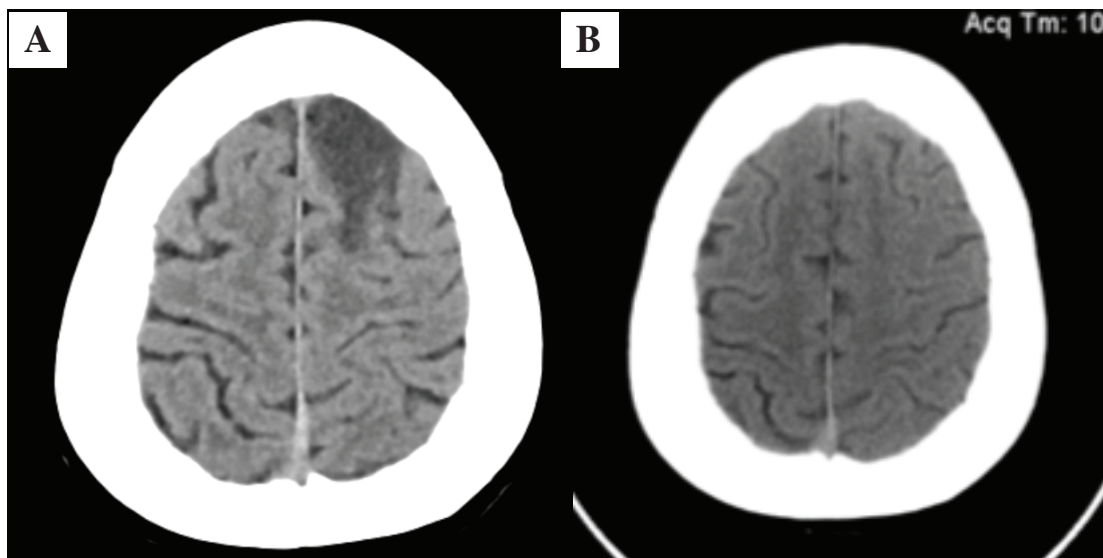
CT (brain) of the patient. A. Axial image showing moderate-sized hypodense lesion over left superior frontal lobe on first admission. B. Disappearance of the lesion on repeat scan 3 weeks after first admission with development of right hemiparesis.
